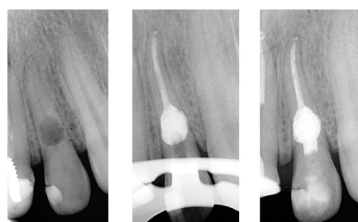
Periapical radiographs of the second case before and after the treatment
